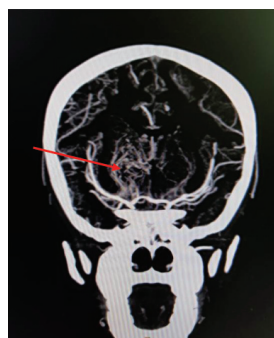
CT angiogram MIP coronal image
